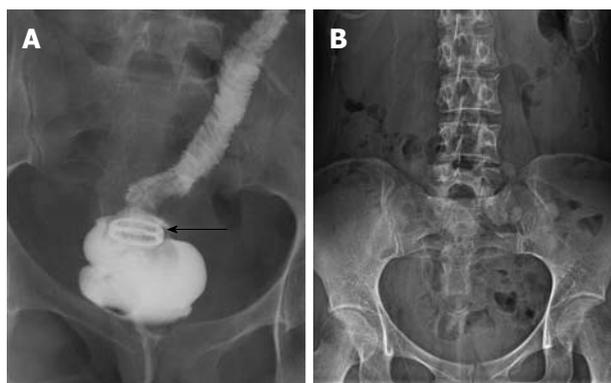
Abdominal radiographs of the patient complicated by anastomotic leakage. A: Gastrograffin study showed complete healing of the anastomotic leakage with the ring (arrow) retained at the anastomosis a week before ileostomy takedown; B: The ring was eliminated from the body spontaneously and was no longer seen on the radiograph nine days after the ileostomy closure.
